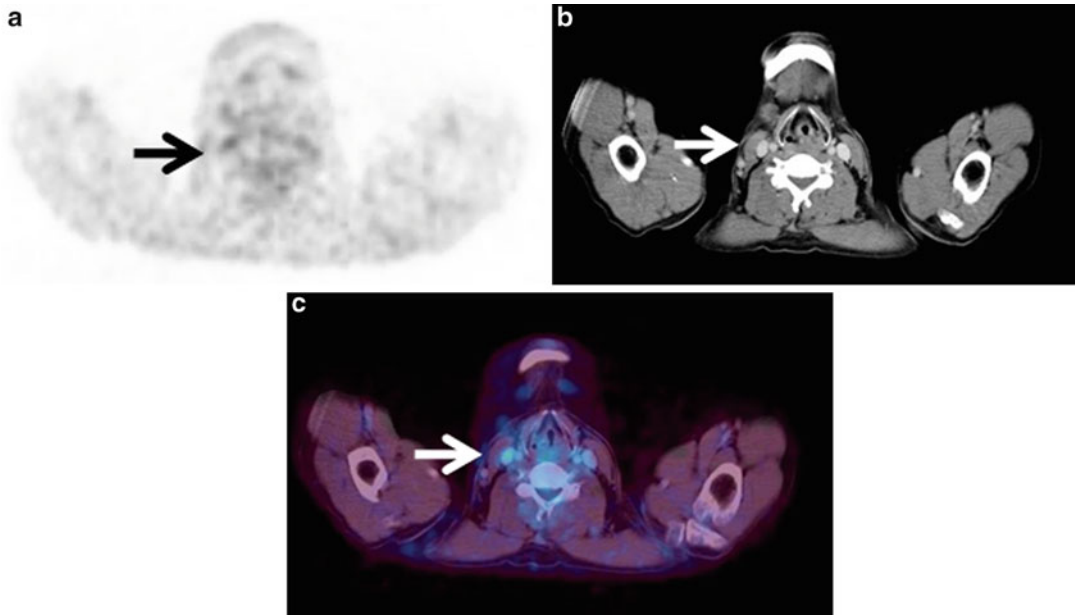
Focal nodal uptake is seen in the right neck on FDG PET (*arrow*). It apparently seems to be lymph node metastasis although CT scan shows intravenous contrast medium in right common carotid artery and internal jugular vein (*white arrow*) at the site
